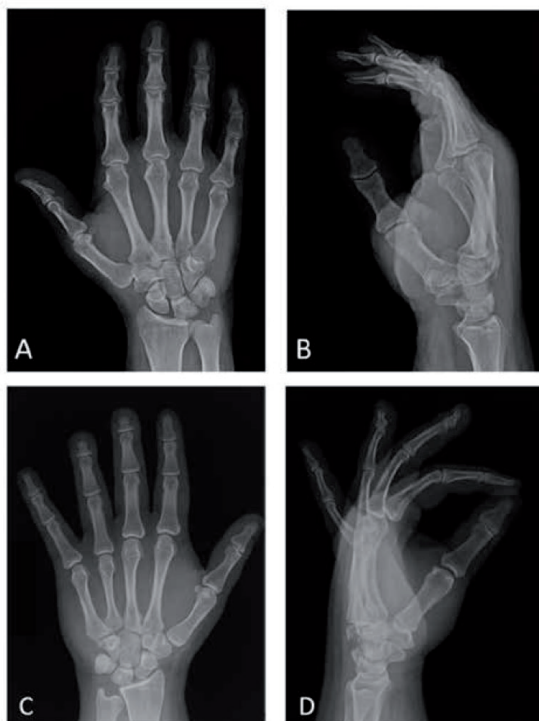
Initial radiographs. (a) Postero-anterior view. (b) Lateral view of patient 1 (diagnosis of fracture-dislocation under-diagnosed by radiologist). (c) Postero-anterior view. (d) Lateral view of patient 3 (diagnosis of fracture-dislocation made by radiologist).
